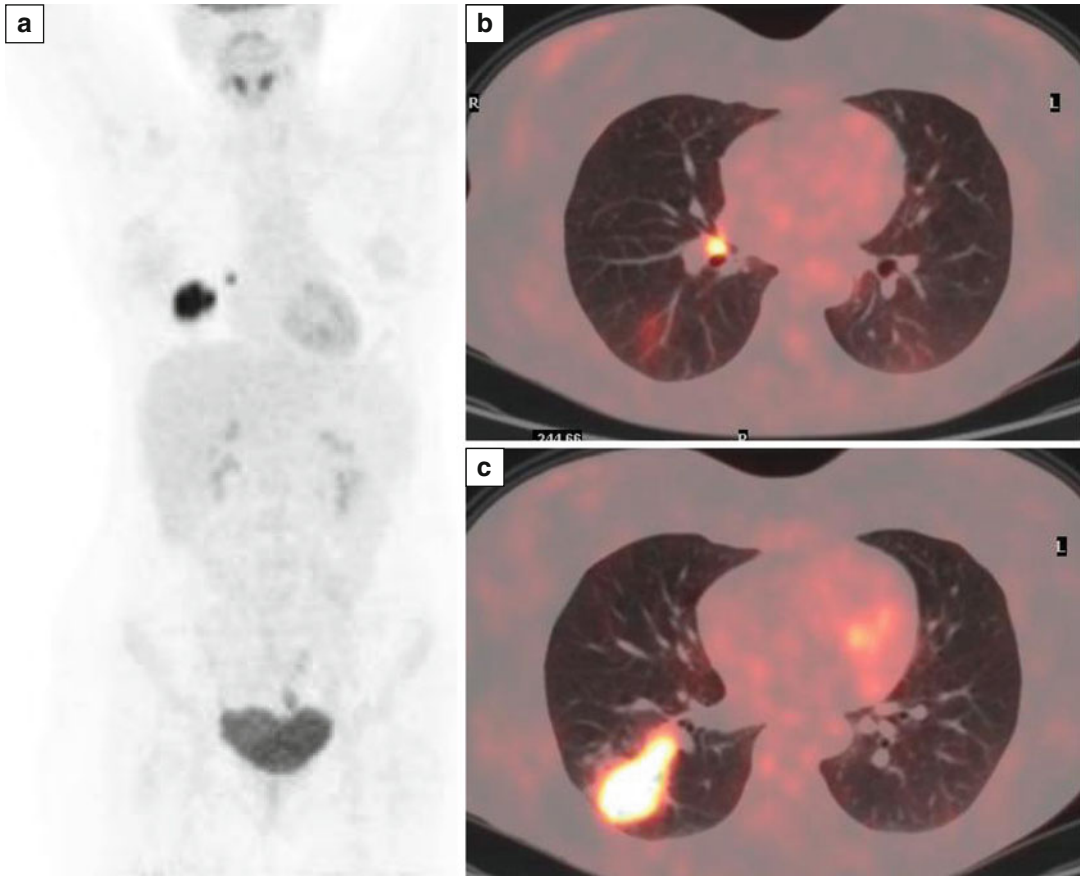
(a–c) MIP-PET and fused PET/CT – after radiotherapy: Small *right* peribronchial lymph node (a, b) and highly hypermetabolic lesion of the right lower lung lobe (a, c)
